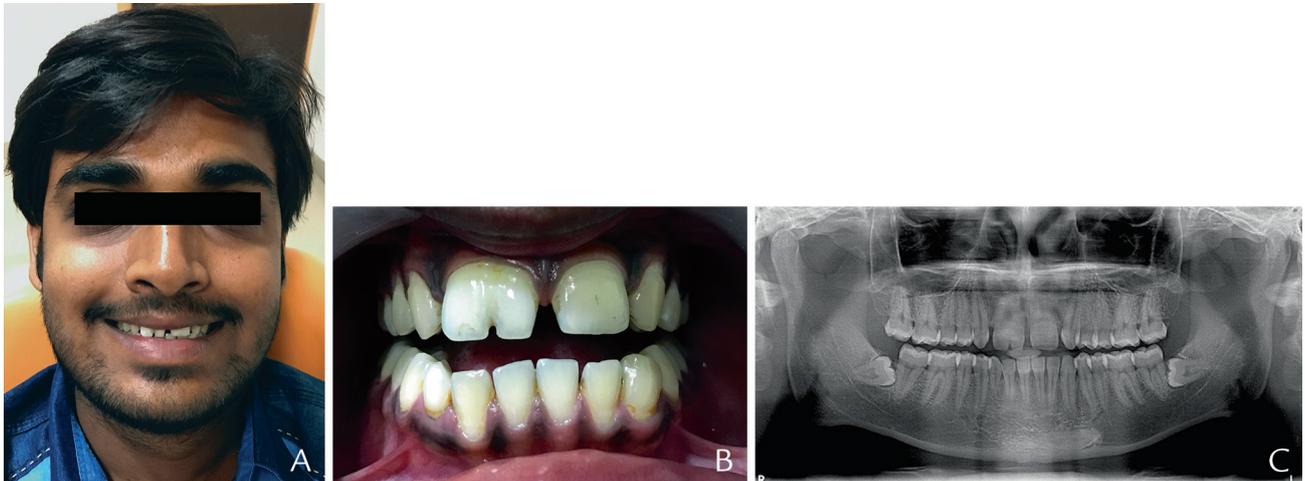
Patient before treatment. A, Extraoral view. B, Intraoral view. C, Panoramic radiograph.
